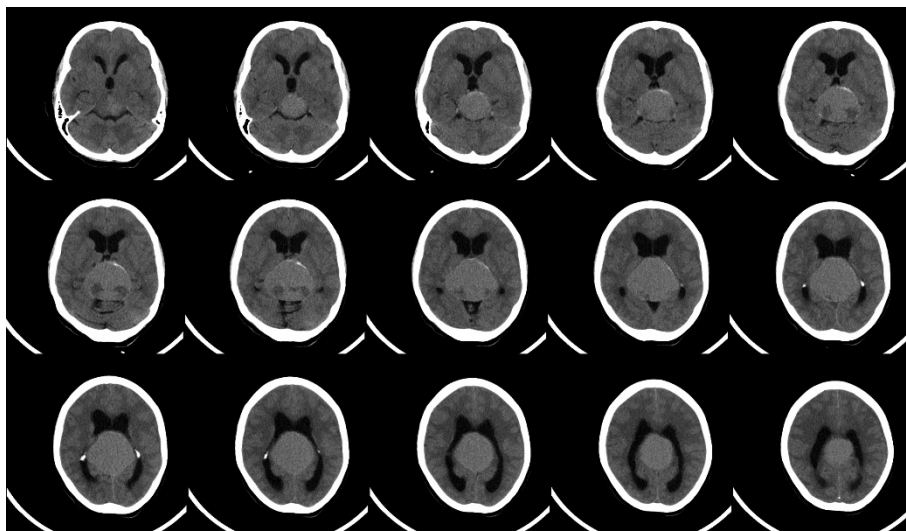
Plain CT scan brain showing a large showing mass lesion in the pineal region with hydrocephalus
